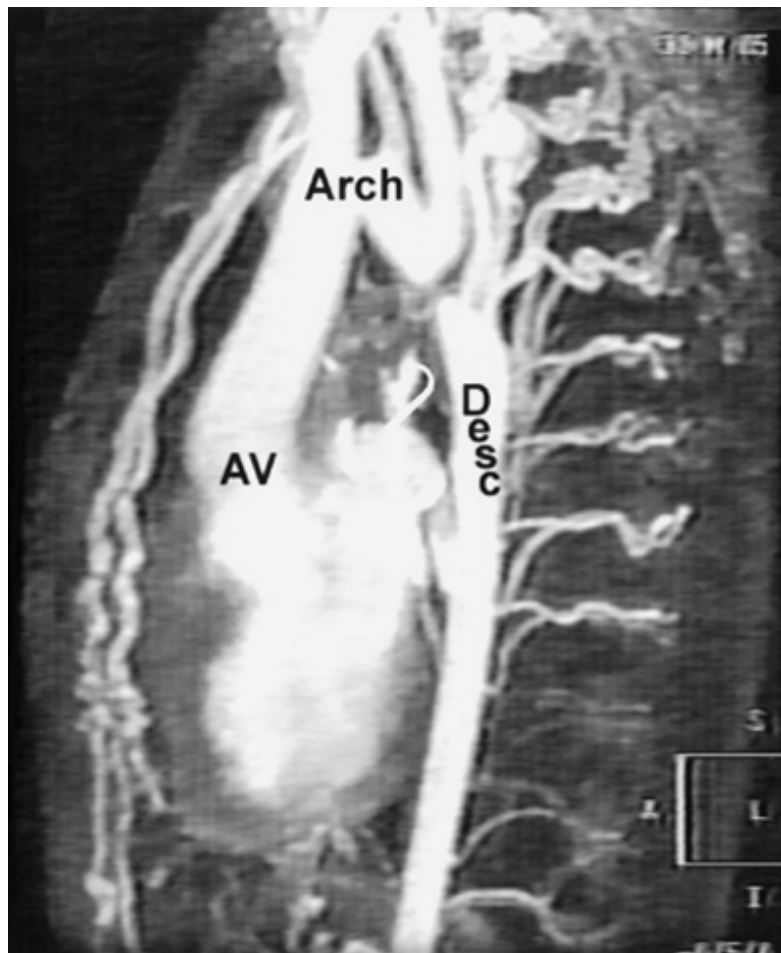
MRI angiogram of a 33-year-old man showing a severe coarctation and development of extensive collateralization involving the intercostal and internal mammary arteries. AV, aortic valve; Desc, descending aorta. (From Oh JK, Seward JB, Tajik AJ. Congenital heart disease. In: Oh JK, Seward JB, Tajik AJ, eds: *The Echo Manual*, 2d ed. Philadelphia: Lippincott-Raven, 1999: 233. Reproduced with permission from the publisher and authors.)
